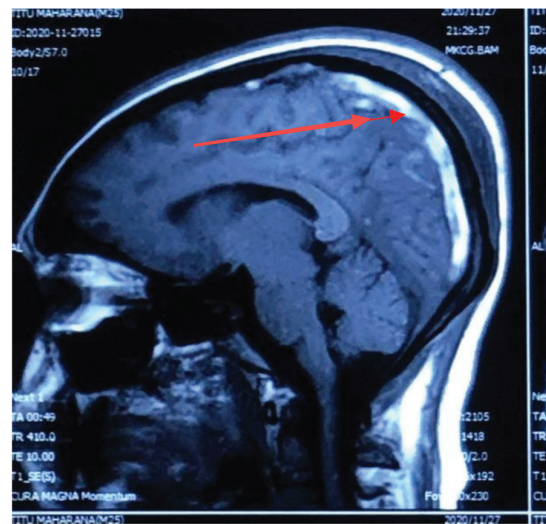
MRI brain showing T1 hyperintensity along superior sagittal sinus, suggestive of thrombosis.(red arrow)
